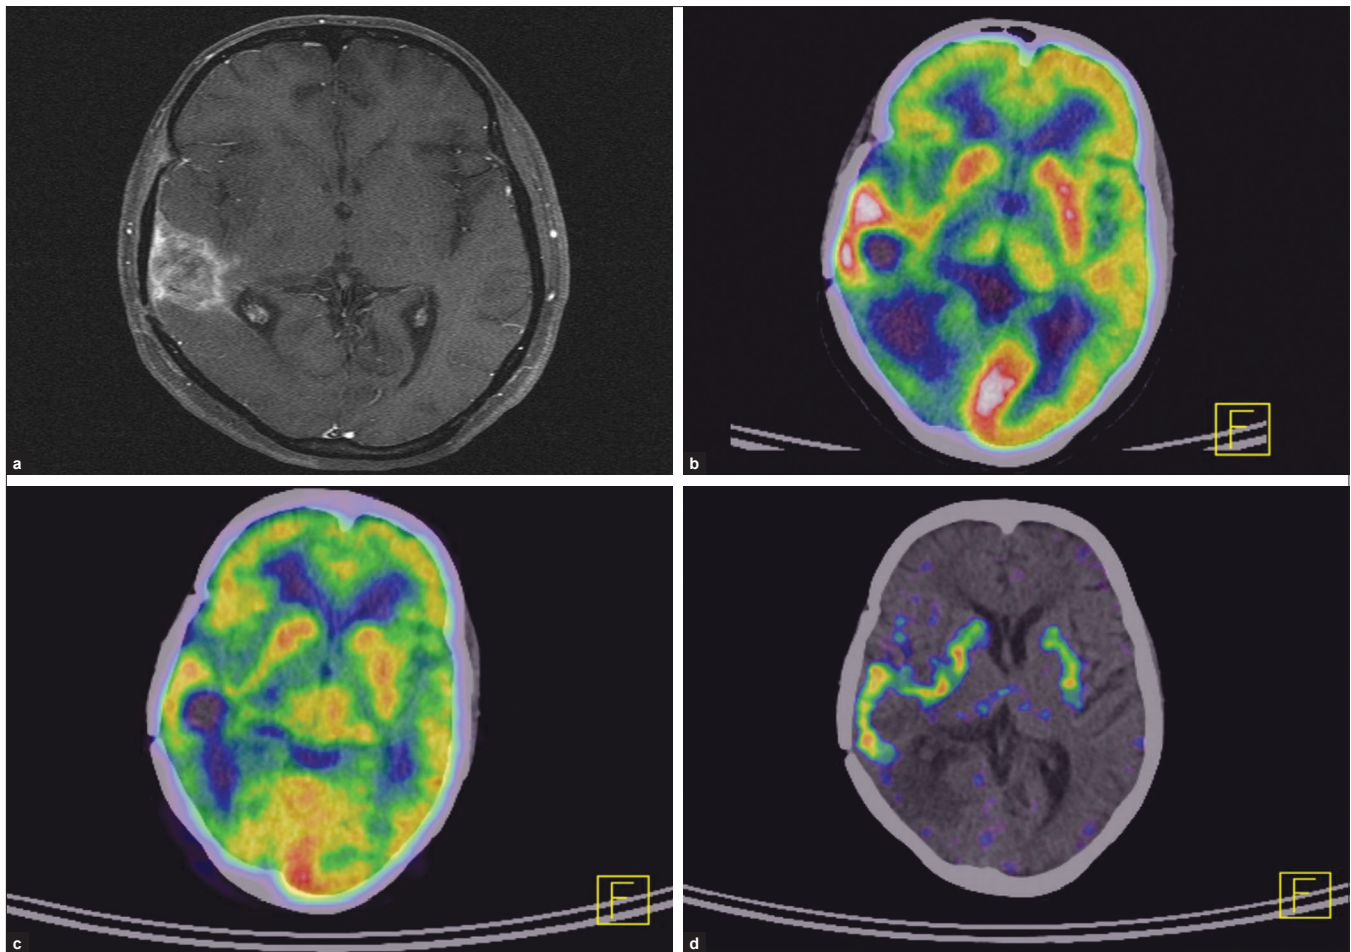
(a) Hypo-intense lesion in RT frontal lobe with mass effect that shows minimal peripheral enhancement. Some of these areas of enhancement are s/o recurrence on MRS; (b) No abnormal FDG avid lesion detected in the corresponding region; (c) No abnormal Ammonia avid lesion detected in the corresponding region; (d) An F-DOPA avid lesion with central hypo-dense hypo-metabolic area in RT frontal lobe causing midline shift of 8mm to left side. The lesion is diffusely extending postero-inferiorly in the parieto-temporal region. Pericallosal spread via genu of corpus callosum to contralateral lobe is seen; (e) F DOPA coronal image shows pericallosal spread via genu of corpus callosum to the Left frontal lobe; typical of butterfly glioma seen in cases of high grade glioma recurrence
